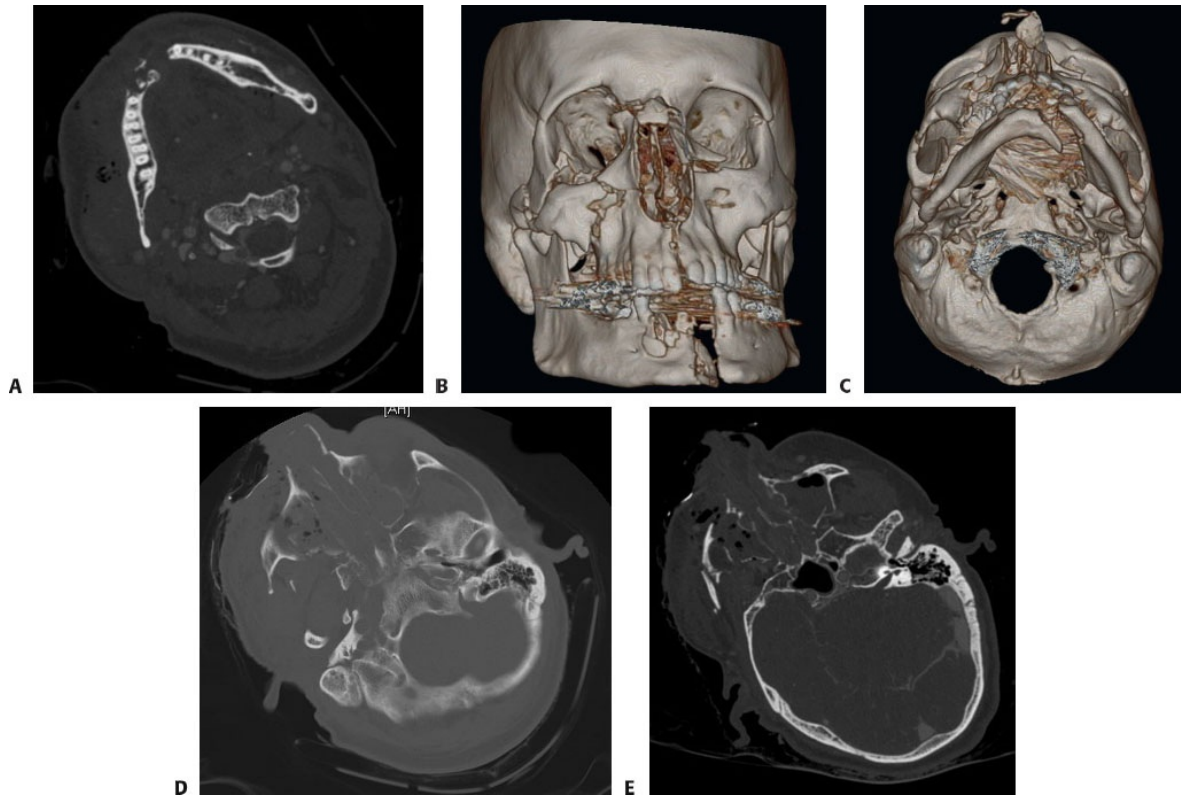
• A. Axial CT imaging can be used to visualize specific fracture patterns. B,C. CT imaging can be reformatted into three-dimensional images that are useful for preoperative planning. D. Craniomaxillofacial CT imaging provides a more comprehensive view of the zygomatic arch as well as the maxilla and mandible. E. Comminuted midface fractures.
